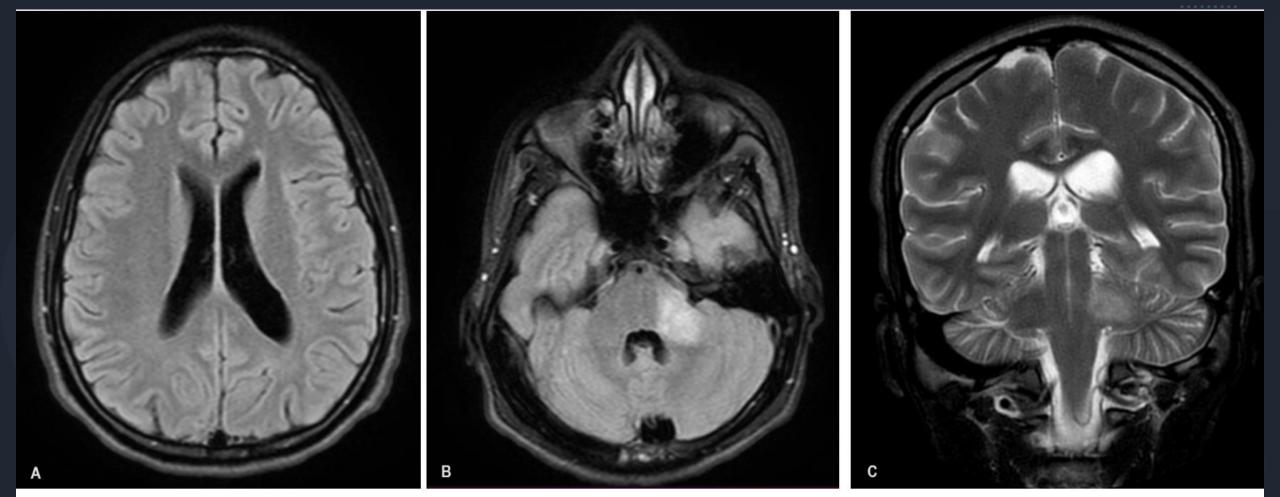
A) Axial FLAIR brain MR- normal. B e C) Axial FLAIR and coronal T2- hypersignal in T2 and FLAIR in left intrapontine trigeminal nerve.
